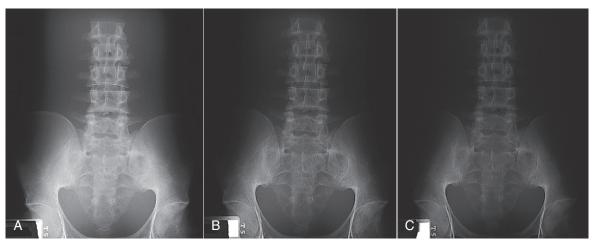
Radiographs of the pelvis and abdomen show that a 4-kVp increase results in a perceptible change in contrast. A, 75 kVp and 28 mAs. B, 79 kVp and 28 mAs. C, 81 kVp and 28 mAs. (Courtesy Mike Enriquez, Merced Community College.)
